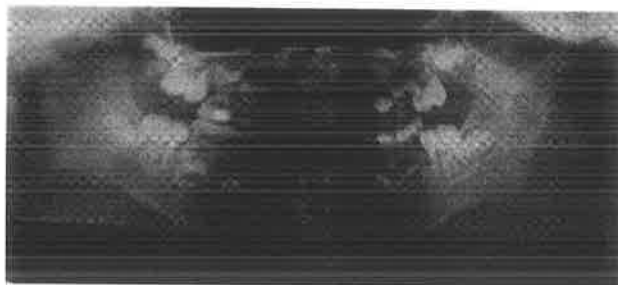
Orthopantomogram exposes the maxillary and mandibular asymmetries and associated open-bite deformities.*
